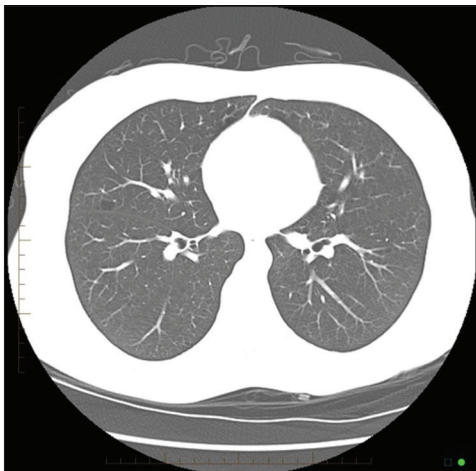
Axial computed tomography chest lung window in 2006 showed few thin-walled cysts in both lungs suggestive of lymphangioliomyomatosis
